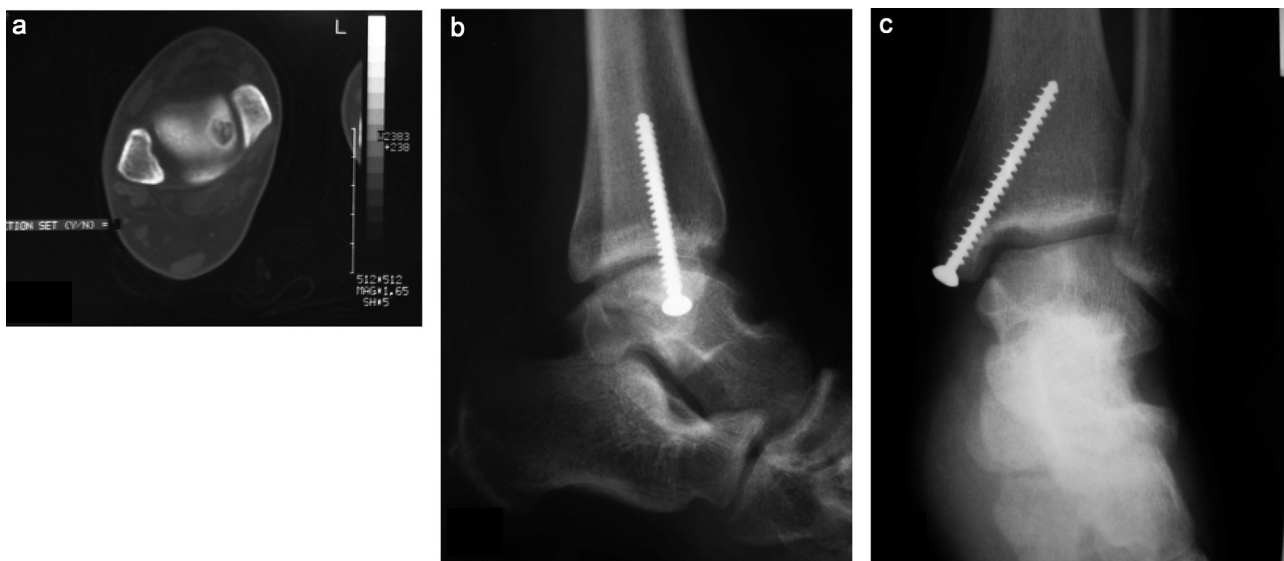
Case no. 5 – Female 14-year old with OO in posteromedial aspect of right talar dome. (a) CT transverse view, (b and c) osteotomy fixation before the removal of the screw.
